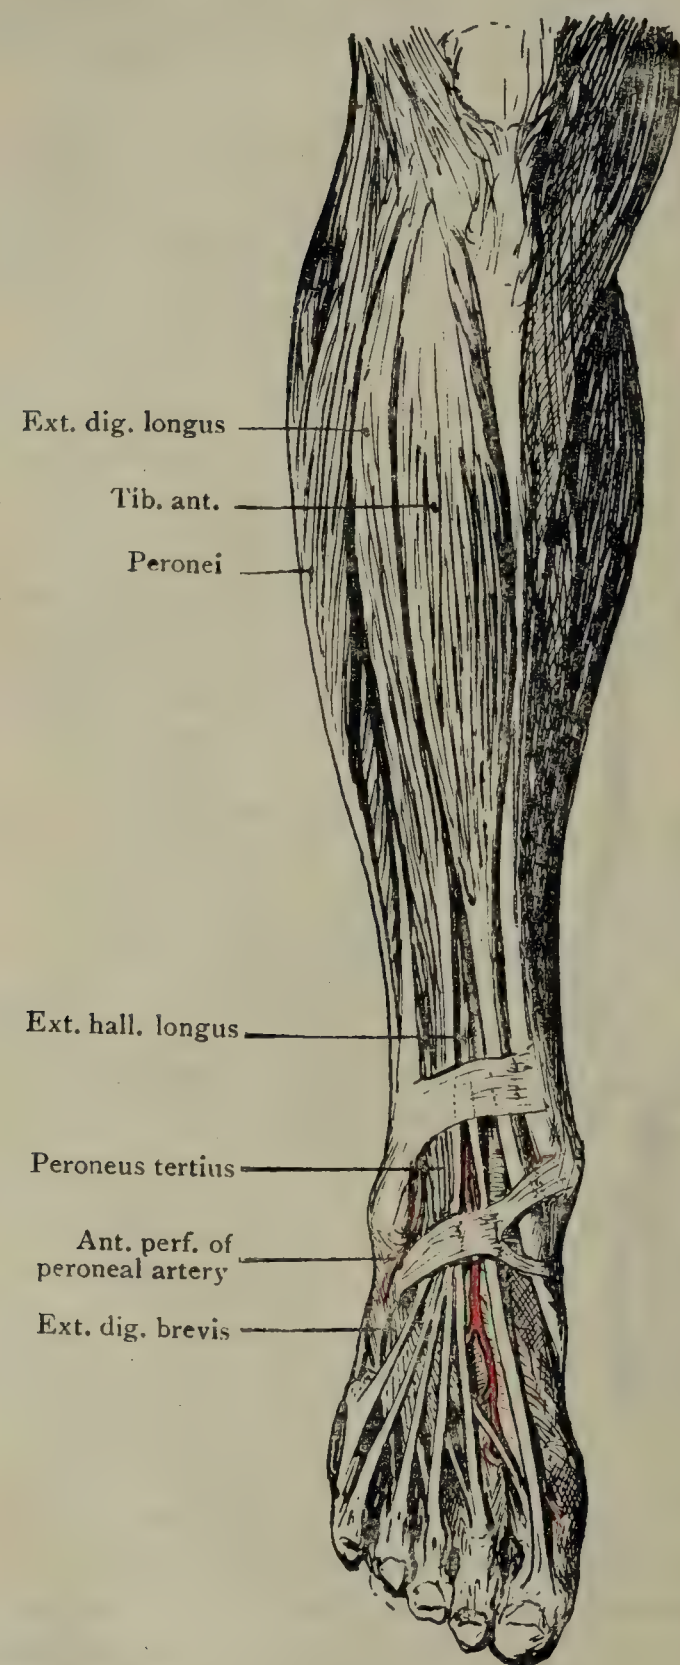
DORSAL ASPECT OF LEG AND FOOT: SUPERFICIAL DISSECTION OF MUSCLES.
